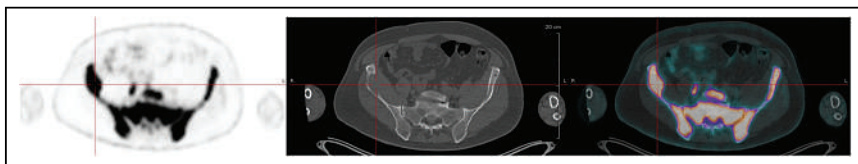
Axial PET (left), CT (middle), and PET/CT (right) images of osteolytic lesion with soft-tissue extension defining paramedullary disease in right iliac wing.
